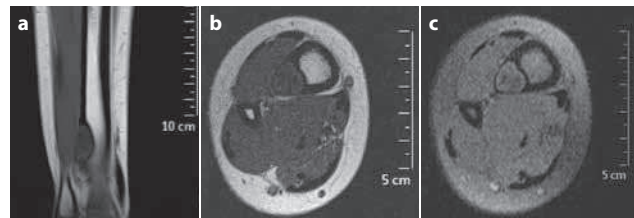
Magnetic resonance imaging (MRI) views showing a low signal relatively homogeneous lesion in the lateral aspect of distal tibial diaphysis, compatible with fibrous or cartilage-type tissue; (a) T1 coronal, (b) T1 axial, (c) PD axial.
